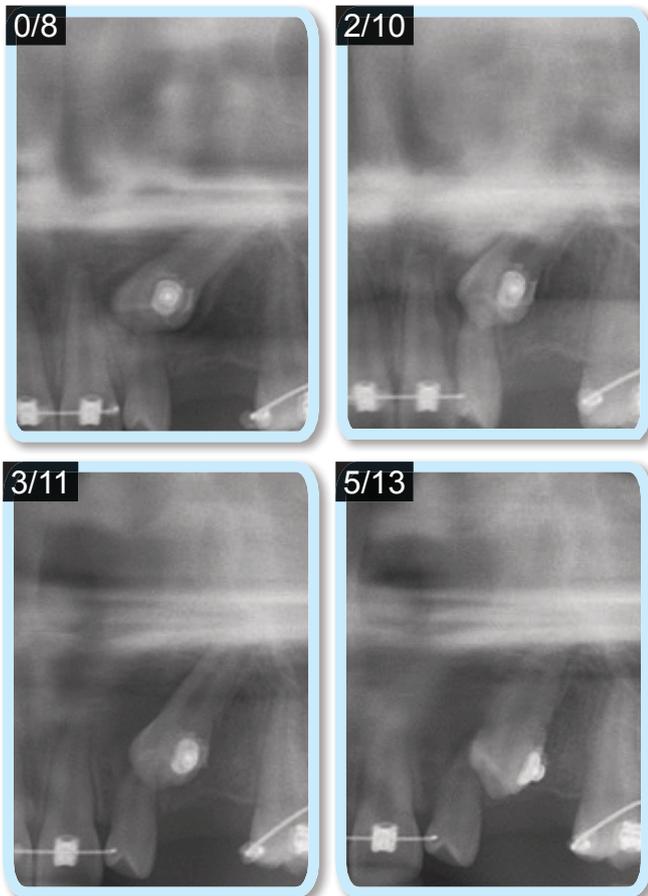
A panel of four radiographs shows progress in the recovery of the impacted UL3. Each radiograph is labeled with a code designating the time in months since VISTA surgery and initiation of traction (first number), and the number of months into active treatment (second number). Thus the upper left view (0/8) is the immediate postoperative radiograph for the surgery performed at eight months into treatment. The lower right image (5/13) shows the position of the UL3 after five months of traction, which corresponds to the thirteenth month of treatment.
